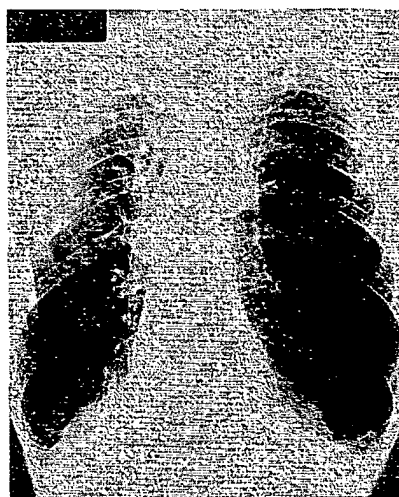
Chest X-ray of a Pi ZZ homozygote with lung emphysema. Notice the flattened diaphragms and the hyperinflated lungs, mainly in the lower lobes. This patient died of respiratory insufficiency at 58 yrs of age. At autopsy, a panlobular type of emphysema was found.
